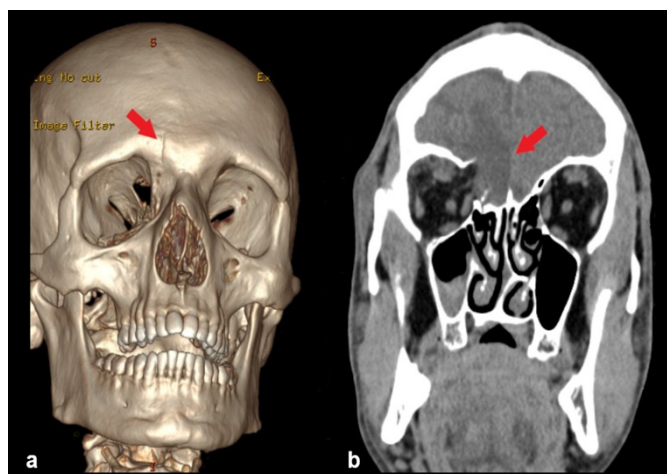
In the 3D computed tomography scan, fracture lines are observed in the medial orbital wall on the right (a), and in the coronal section, densities consistent with oedema and haemorrhage are observed in the right frontal brain parenchyma at this level (b) (red arrows)
